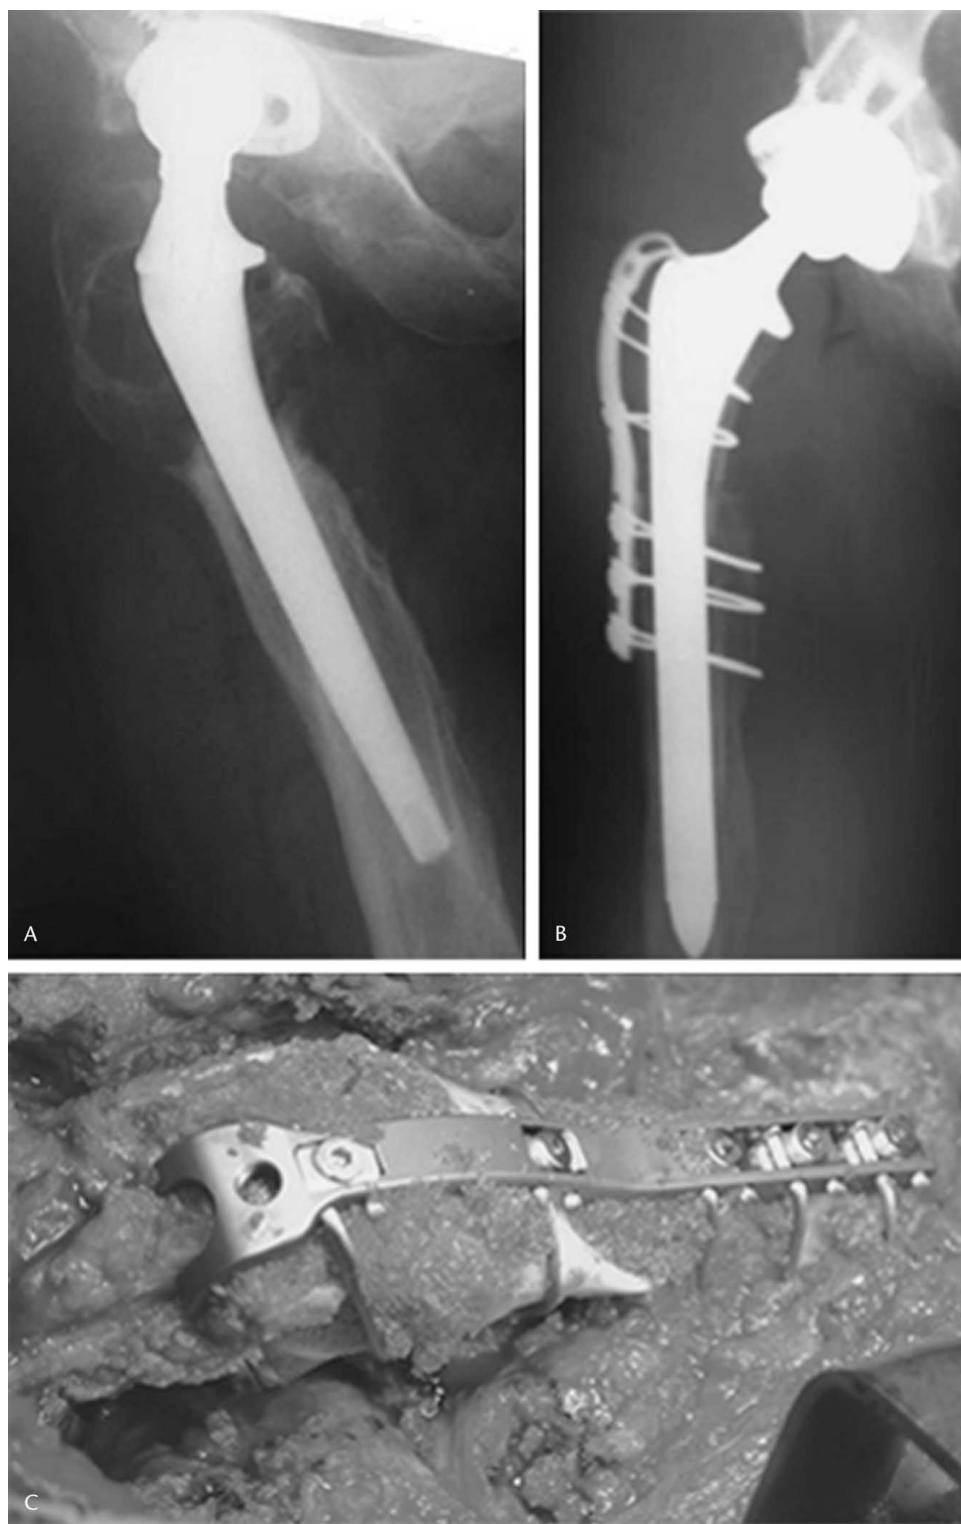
(A) A radiograph shows a failed cementless THA with massive proximal femoral bone loss and trochanteric avulsion. (B) An intraoperative radiograph shows a cable plate securing the trochanter to the structural graft and stabilizing the graft–host bone junction. (C) A corresponding postoperative radiograph.
